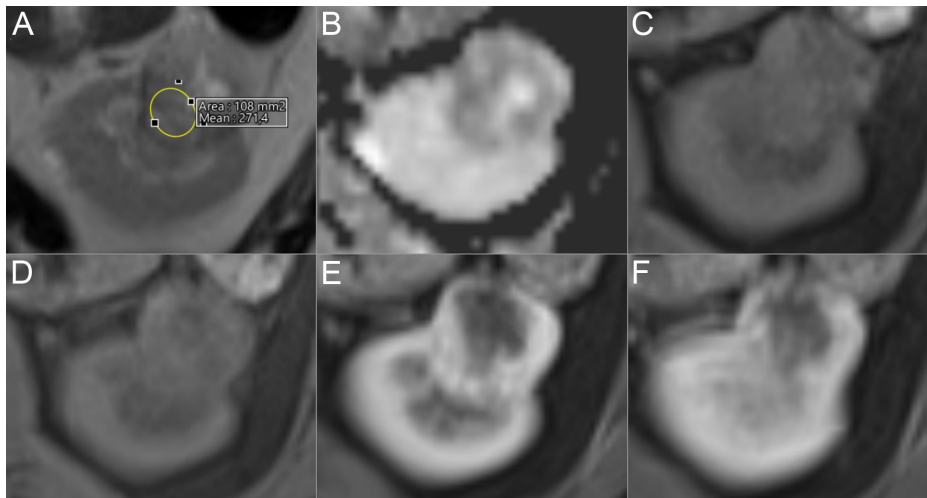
Chromophobe renal cell carcinoma in the left kidney of a 39-year-old man. (A) Axial T2-weighted magnetic resonance (MR) image shows a renal mass with almost the same signal intensity compared to renal parenchyma (T2SIR=98). (B) Apparent diffusion coefficient (ADC) maps show diffusion restriction in the solid areas of renal mass (ADCr=59.5). Axial non-enhanced (C) and contrast-enhanced T1-weighted MR images in corticomedullary (D), nephrogenic (E), and delayed (F) phases show moderate enhancement of the mass without washout (ERc: 122.6, ERn: 126.6, ERd: 128). ADCr, ADC ratio; ERc, corticomedullary phase enhancement ratio; ERd, delayed phase enhancement ratio; ERn, nephrogenic phase enhancement ratio.
